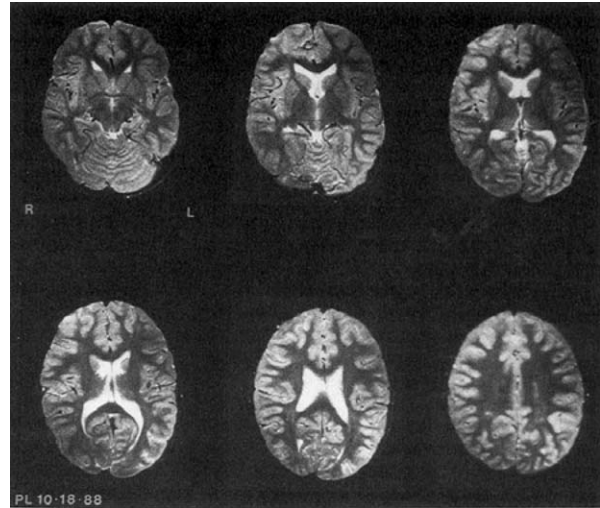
MRI scan of PL showing right prefrontal cortex lesion. Reprinted from *Brain and Cognition*, 20, Marlowe, W. The impact of right prefrontal lesion on the developing brain, 205–213, 1992, with permission from Elsevier.
